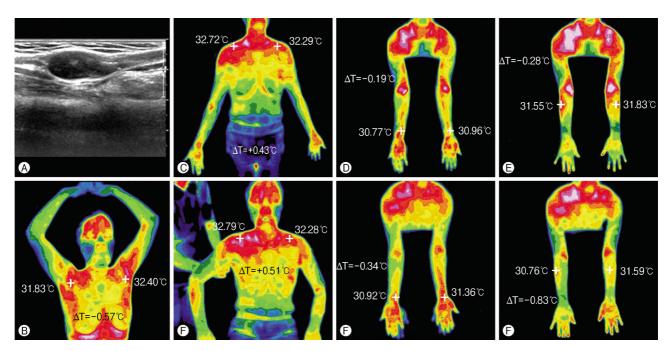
(A) A mass is identified and the size of the mass is measured through ultrasound (about $2.43 \times 1.16 \times 0.8$ cm). (B) Hypothermia around the mass in Rt. axillary. (C) Hyperthermia on the anterior body side without compression test ($\Delta T=0.43^{\circ}$ C). (D) Hypothermia on distal area of upper extremity according to proximal ulnar nerve ($\Delta T=-0.19^{\circ}$ C). (E) Hypothermia on distal area of wrist according to distal ulnar nerve ($\Delta T=-0.28^{\circ}$ C). (F) With compression test, hyperthermia on the anterior body side ($\Delta T=0.51^{\circ}$ C). (G) After compression test, hypothermia on distal area of wrist according to proximal ulnar nerve ($\Delta T=-0.34^{\circ}$ C). (H) After compression test, hypothermia on distal area of wrist according to distal ulnar nerve ($\Delta T=-0.34^{\circ}$ C). (H) After compression test, hypothermia on distal area of wrist according to distal ulnar nerve ($\Delta T=-0.84^{\circ}$ C).
